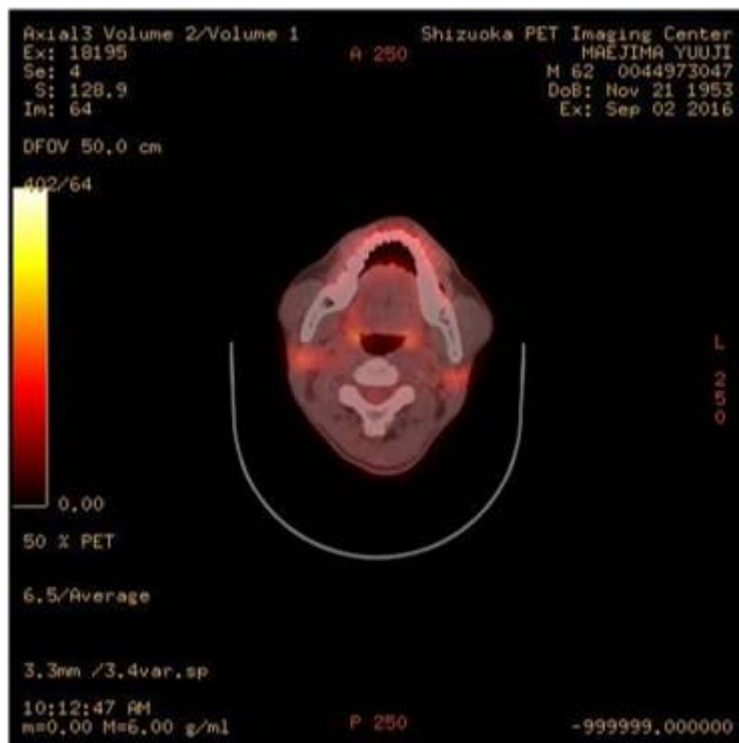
PET-CT showing no obvious abnormalities of tumour and lymph node
